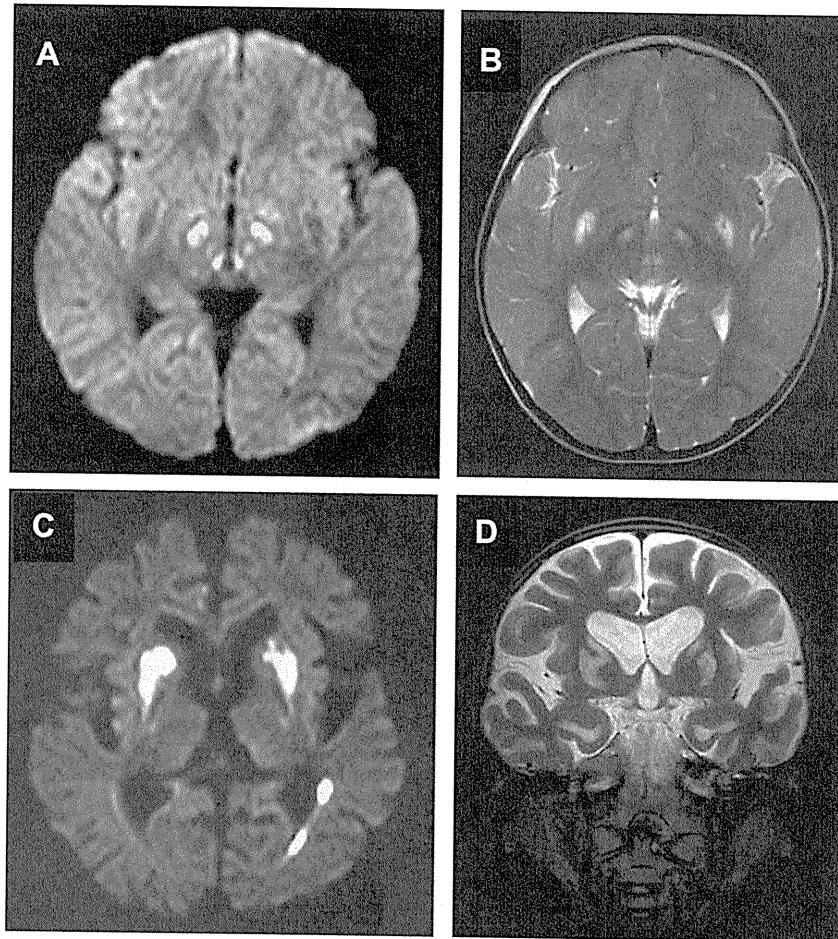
Diffusion-weighted (A and C) and T2-weighted (B and D) magnetic resonance imaging of the brain in Case 1 at 2 years and 5 months of age (A and B), and in Case 2 at 7 years and 6 months of age (C and D). In Case 1, the bilateral substantia nigra (A), subthalamic nucleus (A and B), red nucleus (A), medial parts of the midbrain (A and B) and putamen (B) show the signal hyperintensity. In Case 2, bilateral striatum reveal hyperintensity (C and D). The left optic radiation is also involved in Case 2 (C) and the global cerebral hemisphere is atrophic (C and D).
